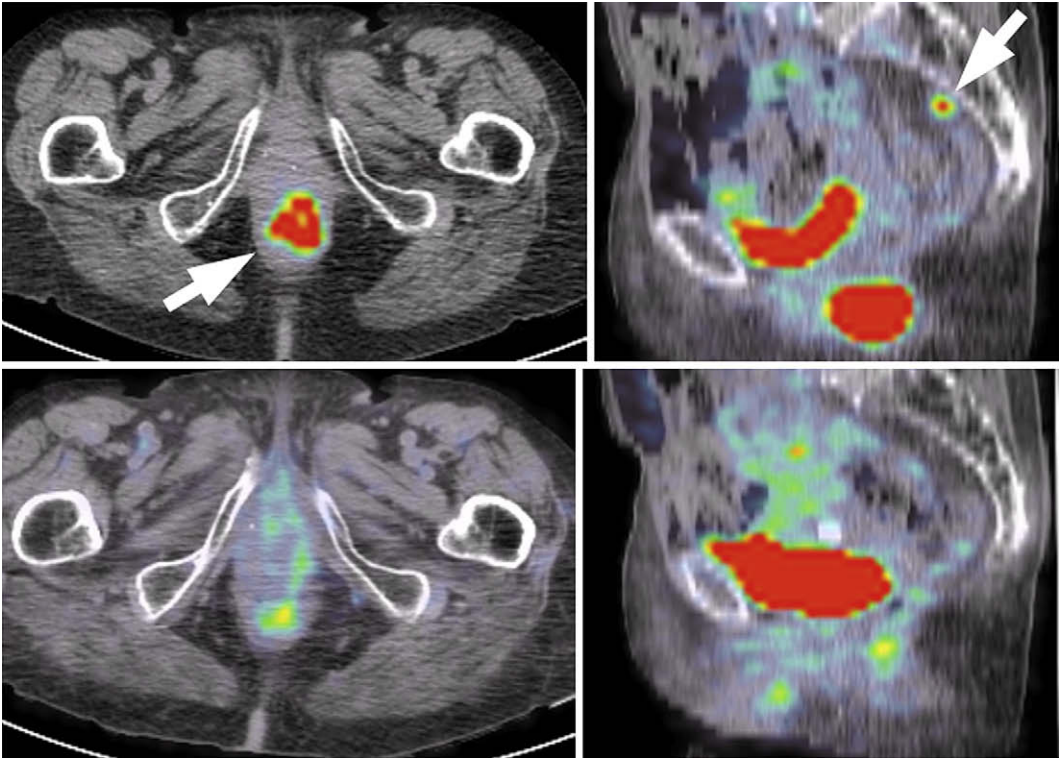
Pre- and posttherapeutic FDG PET-CT of a 90-year-old woman with anorectal cancer. (*Top*) Baseline PET-CT showing a high uptake in the primary tumor (primary tumor standardized uptake value 12), and a positive lymph node in the presacral basin (*arrows*). (*Bottom*) FDG PET-CT obtained 11 weeks after completion of radiotherapy (60 Gy) delivered on the primary tumor and PET-positive lymph nodes. There is a good metabolic response at the primary tumor level (primary tumor standardized uptake value drops to 3.1). The large reduction in the primary tumor standardized uptake value at the primary level (−75%) together with the complete disappearance of the presacral hot spots classify the patient as responder.
